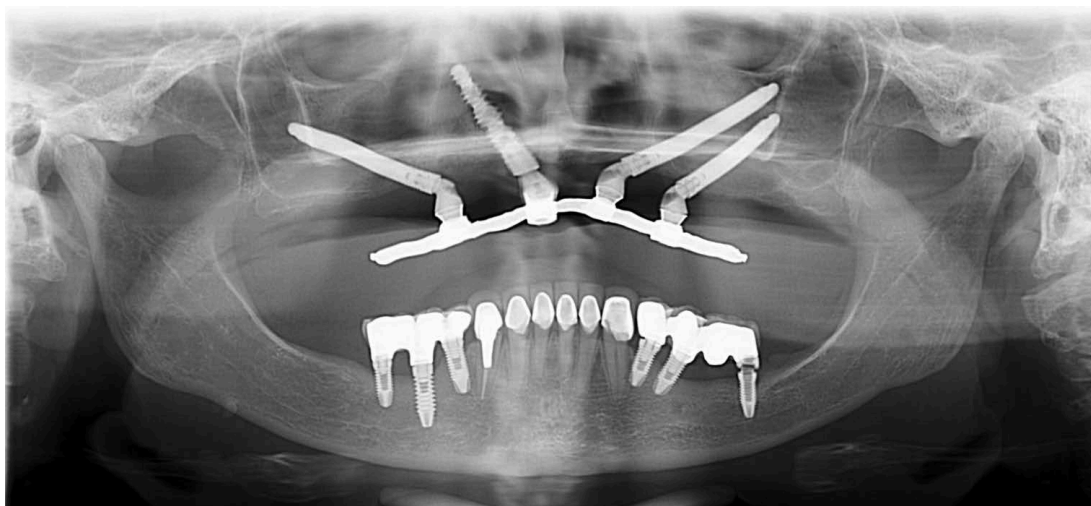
Postoperative panoramic radiography, showing the final result of the rehabilitation.
